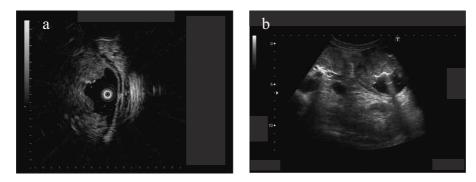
Endoscopic (a) and transabdominal (b) ultrasonography showed an isoechoic mass located in the mucosal and submucosal layers and invaded partially into deeper layer.
